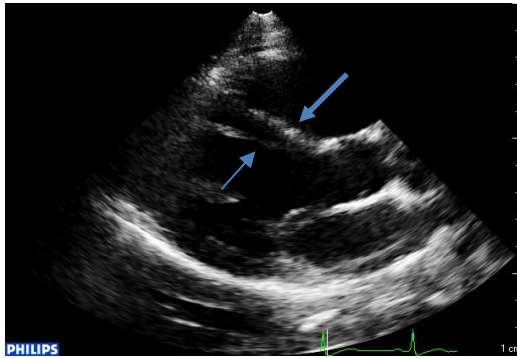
False tendon in parasternal long axis view
